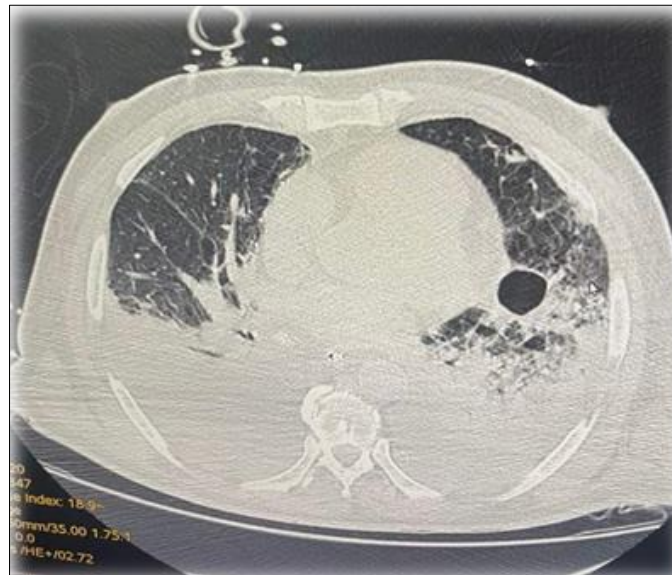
Cross-section of a chest CT scan showing an atypical cavitory image
